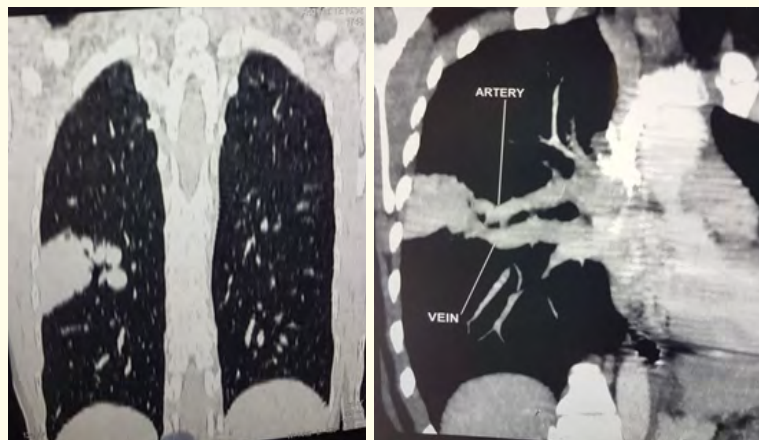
HRCT Chest shows right lower lobe apical segment arteriovenous malformation of size 3cm by 3.6 cm by 4.4 cm.
